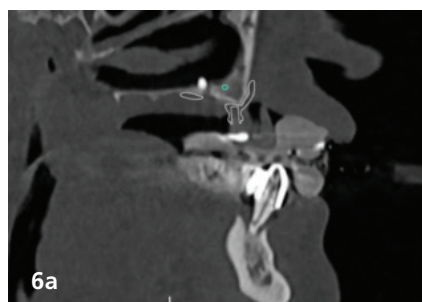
The original bite, called the "3D bite", within the radiopaque markers is used during the CBCT acquisition to obtain the alignment between the rendering from the CBCT and the STL from the models.
